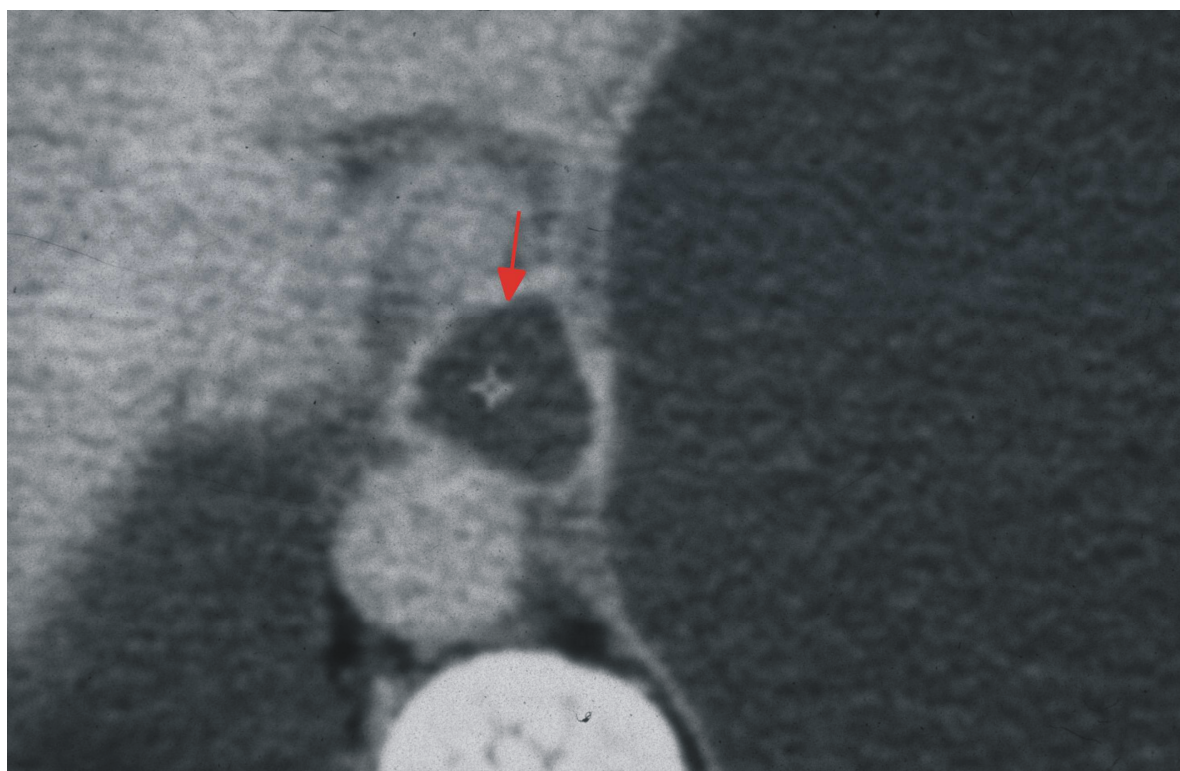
CT -- above the diaphragm fistulous channel is enlarging, it passes through the posterior mediastinum and adheres to mediastinal pleura. Bilateral fluidothorax is present.
